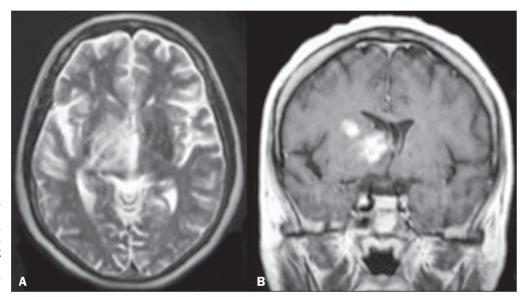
Female patient diagnosed with Behçet's disease. Contrast-enhanced T2-weighted and T1-weighted MRI scans of the skull showing a subcapsular lesion with an expansile effect in the right thalamus, extending to the subthalamus and right cerebral peduncle, with diffuse, heterogeneous contrast enhancement.
